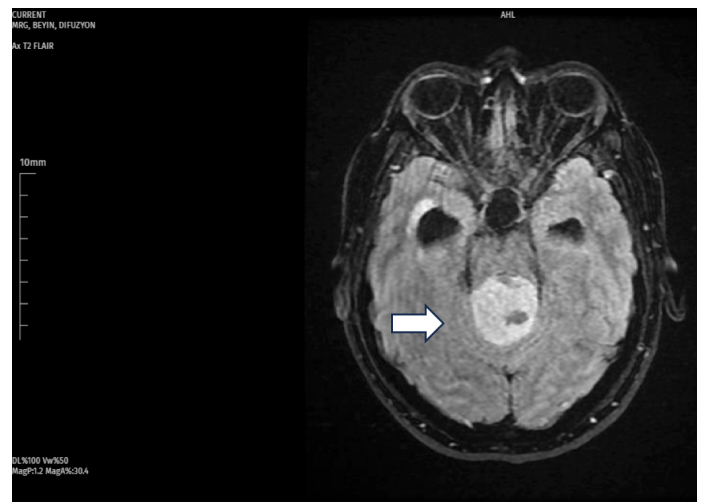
Axial plane of brain magnetic resonance imaging. Intracranial mass located at the 4th ventricle (arrow).
